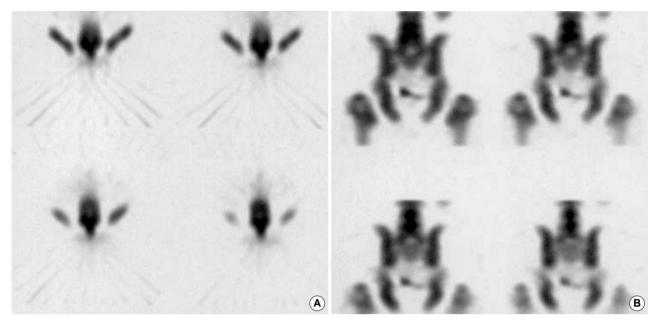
Transverse (A) and coronal SPECT (B) slices through lower lumbar spines and pelvis show intense tracer uptake on the both laminae and spinous processes of L4 and L5.
